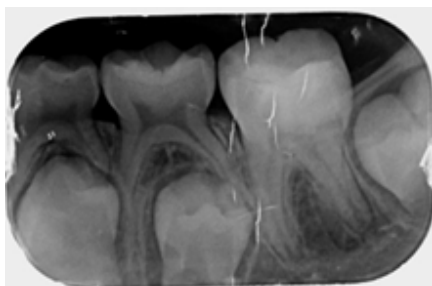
Periapical radiograph control of definitive restoration of 3.6.*
